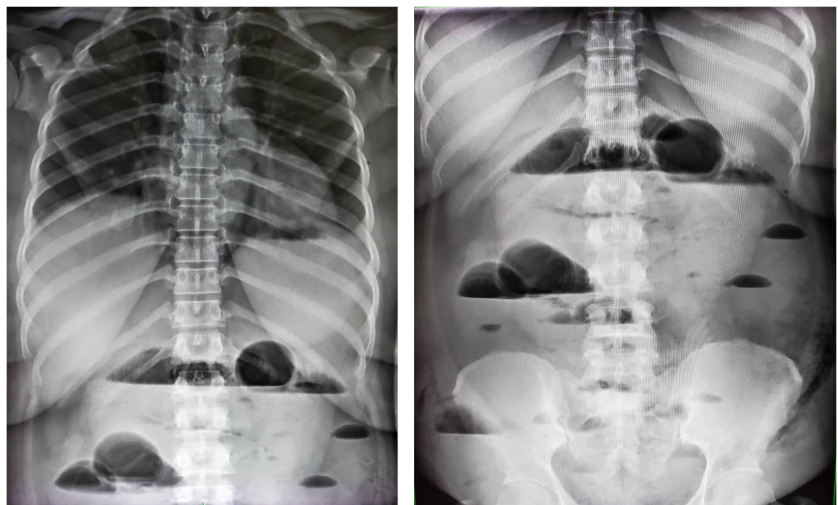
Thoraco-abdominal X-ray and ASP from the front, patient standing, showing centro-peripheral hydro-aerial levels wider than high of hail origin.
